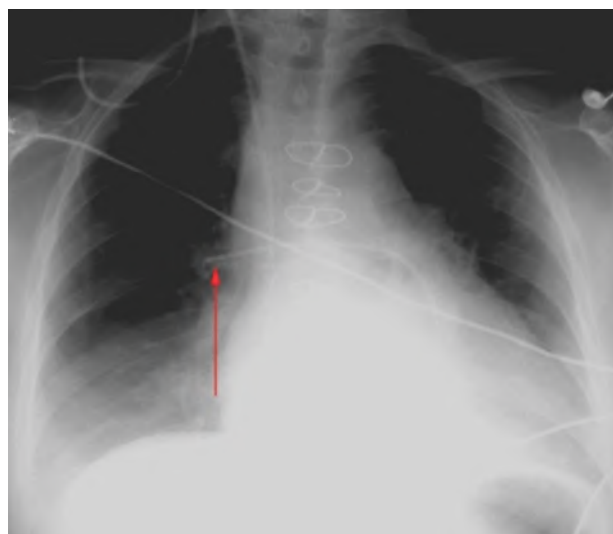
A. Chest x-ray showing location of Swan-Ganz catheter tip (arrow) in the right pulmonary artery (red arrow).
